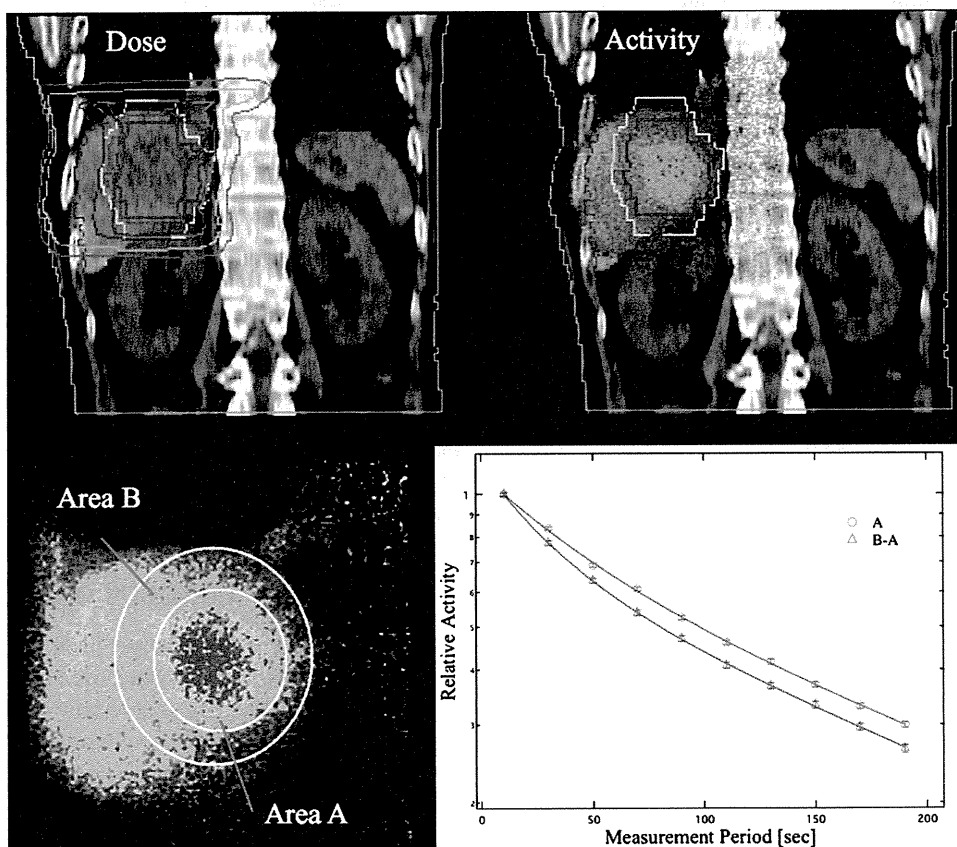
The calculated dose distribution and the measured activity distribution on a CT image after the first treatment with a 3.8-GyE delivery dose, and the number of detection counts per 20 seconds of the activity in the region of interest (ROI) of areas A and B in the liver.
